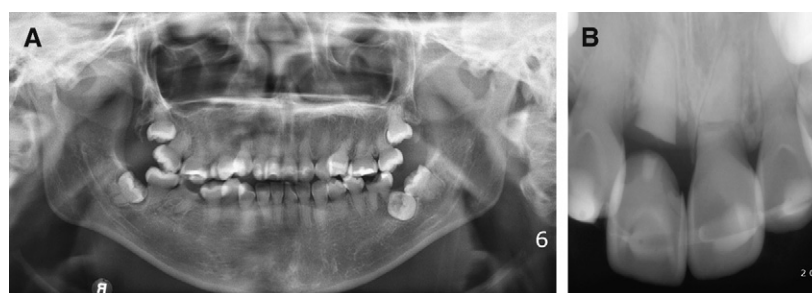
A, Panoramic radiograph and B, periapical radiograph of the maxillary incisors at pretreatment.
